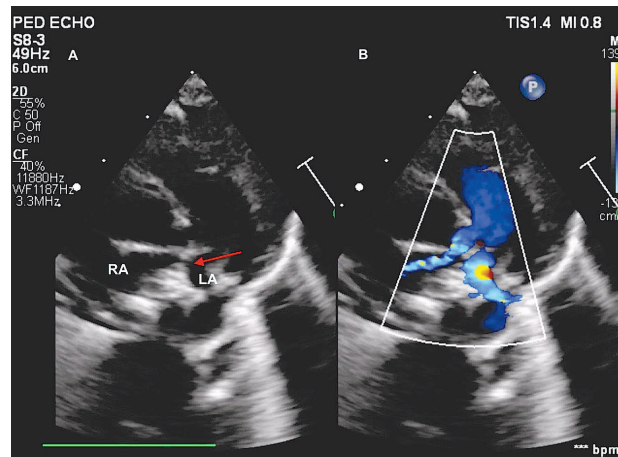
Apical four-chamber view on 2D echocardiography highlighting a small ASD identified during the neonatal period, which resolved spontaneously
